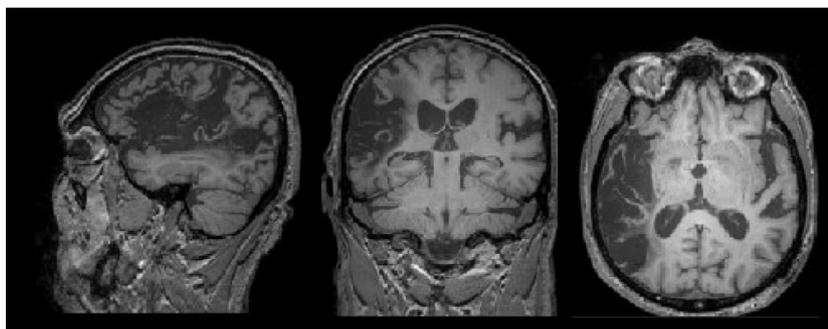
MRI scan for JCB.
